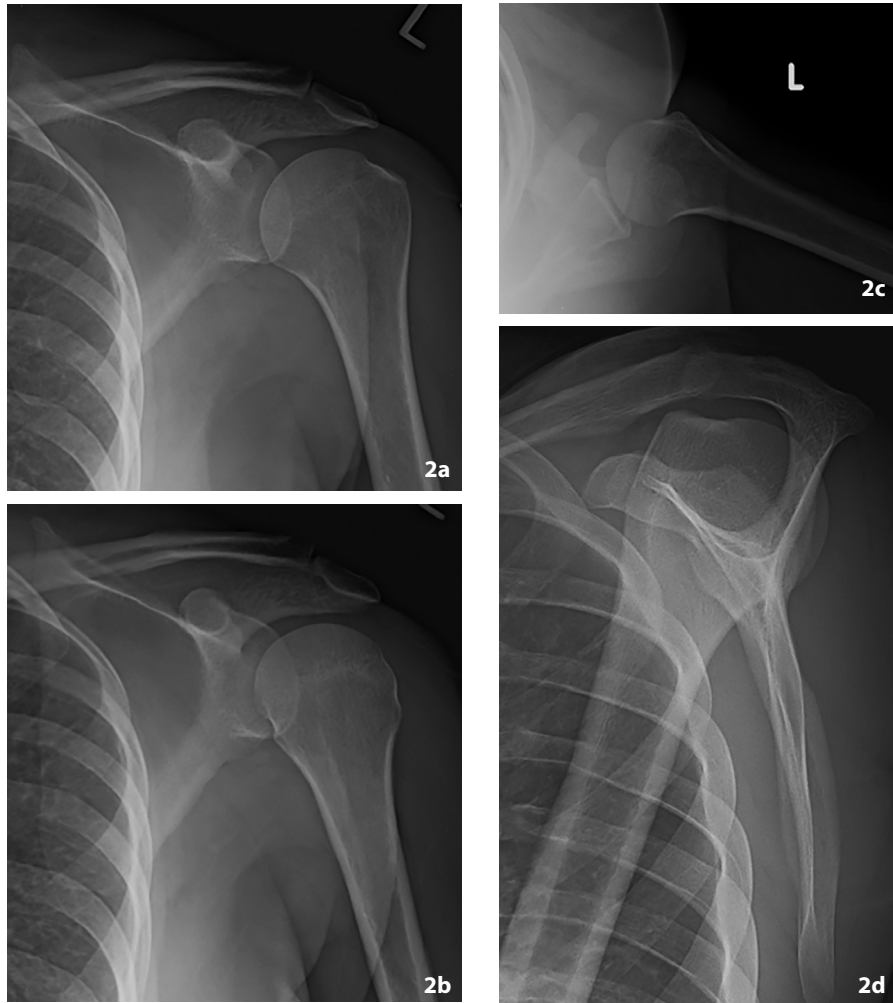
Routine shoulder radiographs. The complete radiographic examination of the shoulder consists of anteroposterior (AP) radiographs in (a) external rotation and (b) internal rotation and (c) an axillary view. When an axillary view cannot be obtained due to pain and difficulty with arm abduction, (d) a scapular “Y” view may be obtained.
